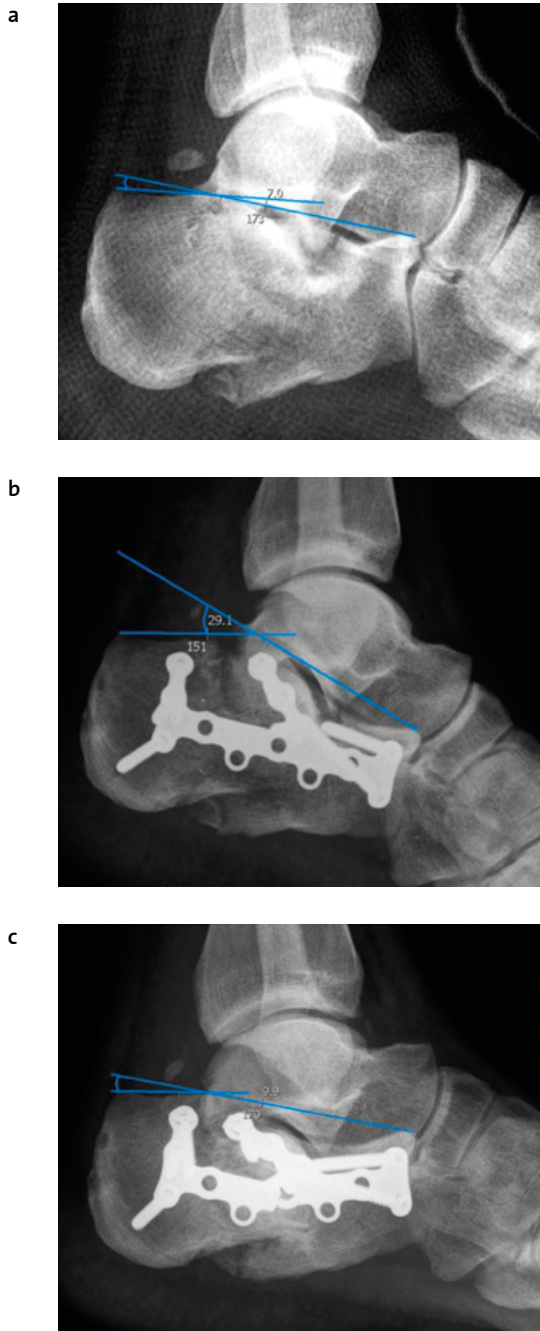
Böhler's angle (BA) is the angle from the intersection of an imaginary line joining the highest point of the anterior calcaneal process and the highest point of the posterior talocalcaneal joint, with a line drawn from the most superior point of the posterior talocalcaneal joint to the highest point of the calcaneal tuberosity, as measured on lateral foot radiograph. a Preoperative BA of 7°. b Postoperative BA of 29°. c Calcaneal collapse of 10° at one year follow-up.
